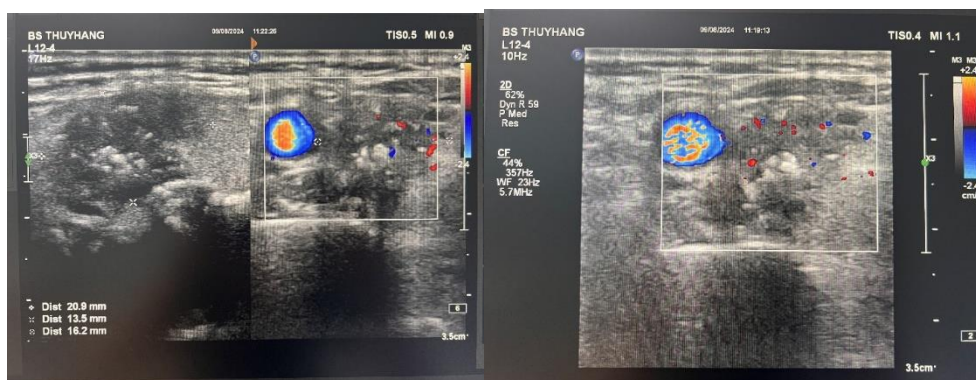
Ultrasound of the right thyroid lobe showing a solid hypoechoic nodule with irregular margins, punctate echogenic foci, and coarse calcification, categorized as ACR TI-RADS 5
